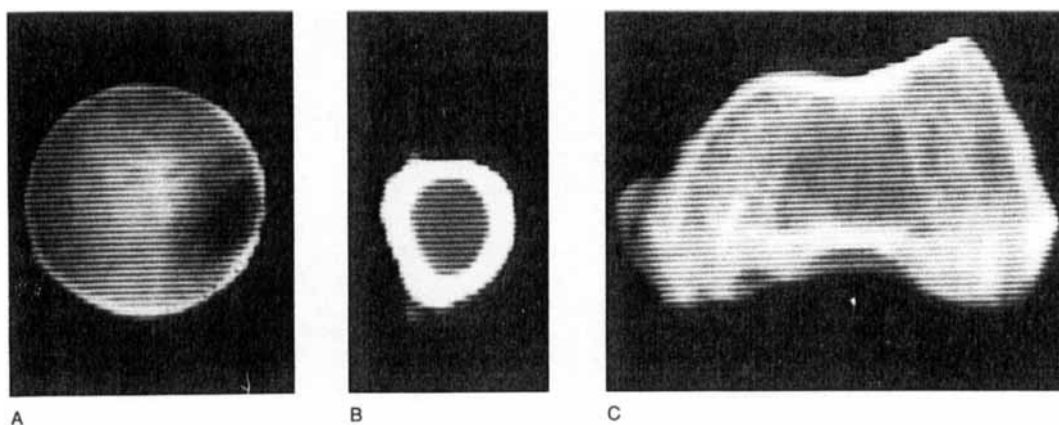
CT slices through the femoral head (A), mid-diaphysis (B), and condyle (C).
